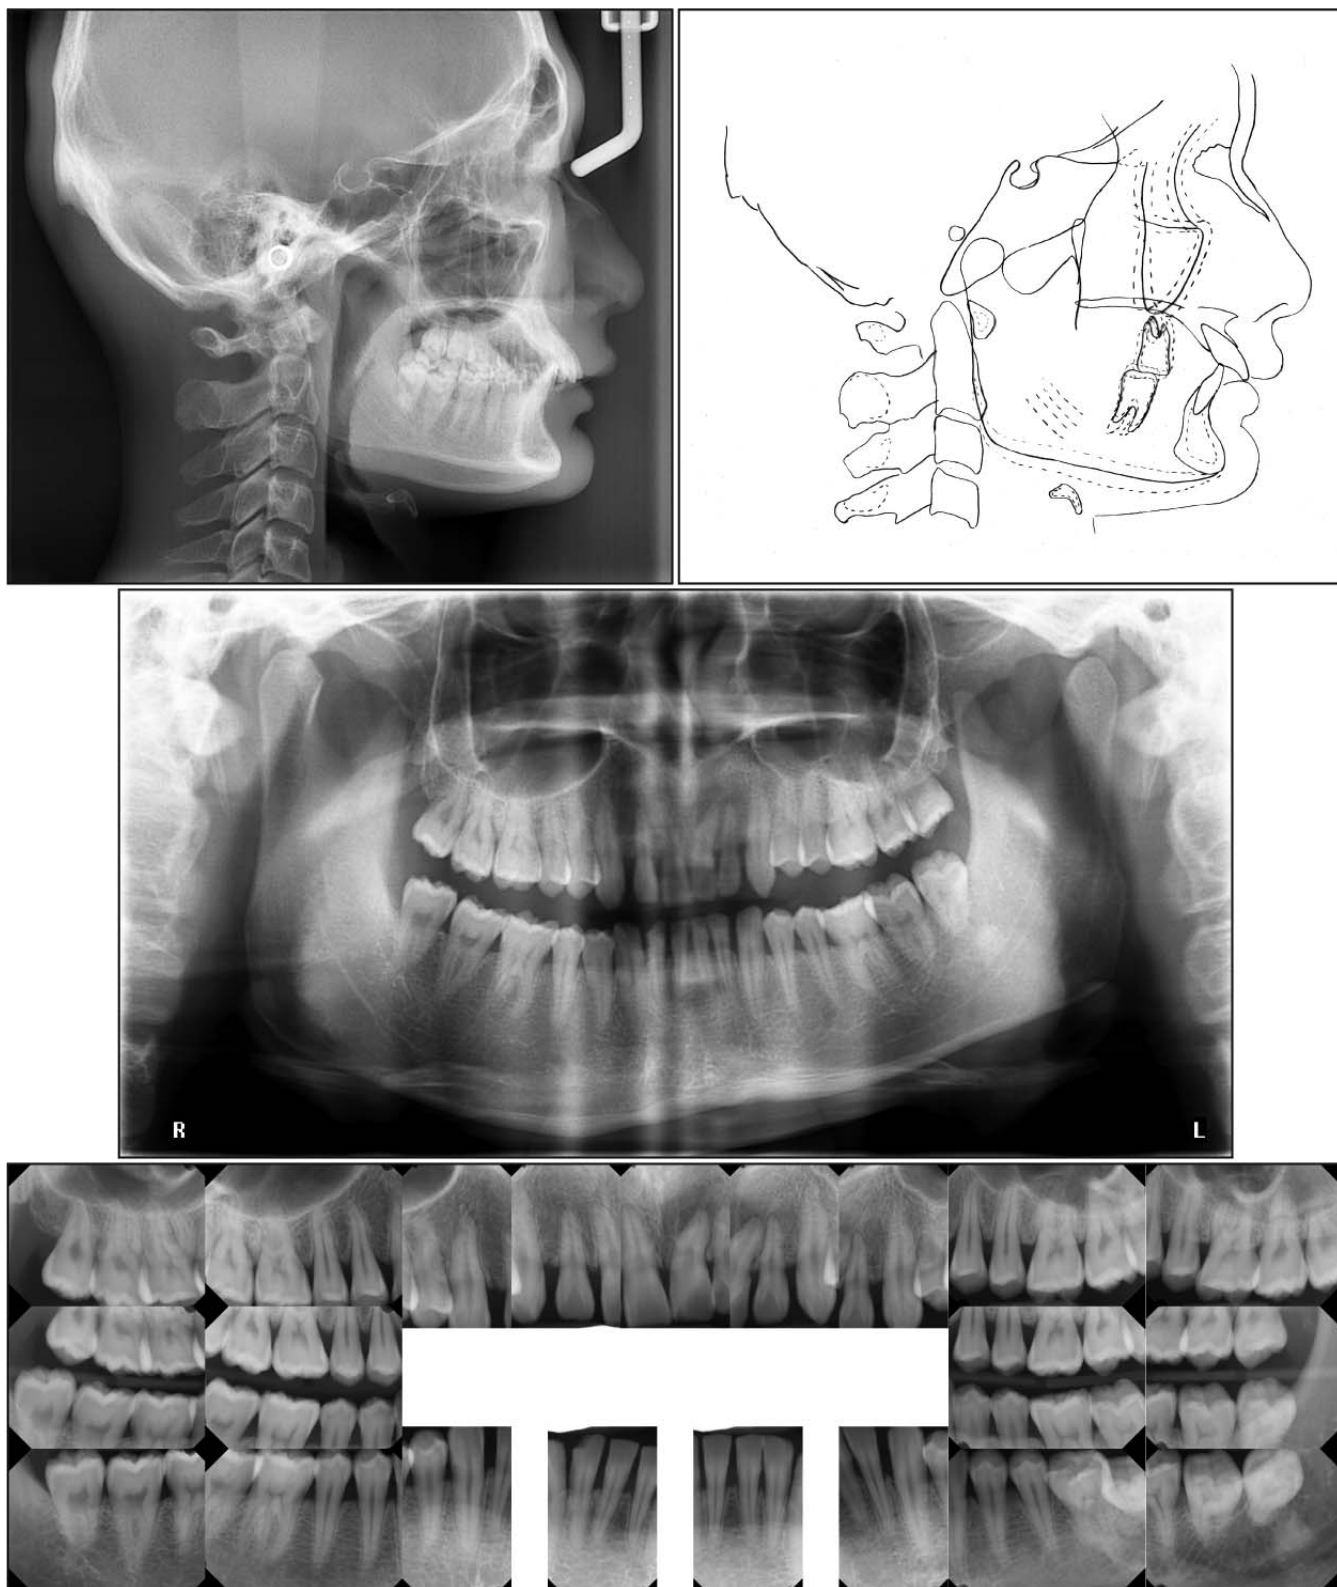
Pretreatment lateral cephalometric radiograph, cephalometric tracing, panoramic radiograph, and full-mouth series x-rays.
